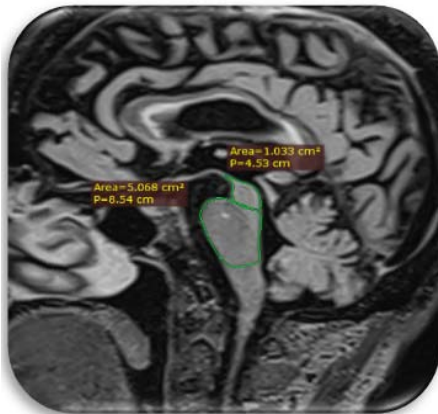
Sagittal section in FLAIR showing the mesencephalic atrophy.
